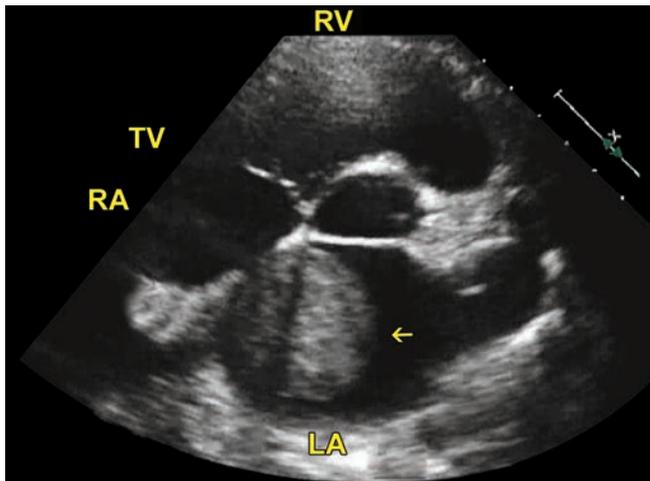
Transthoracic echocardiography. Parasternal short axis around the level of the aortic valve. (RA: Right atrium; LA: Left atrium; RV: Right ventricle; TV: Tricuspid valve). Arrow points to a mass attached to the left atrial surface of the interatrial septum.
